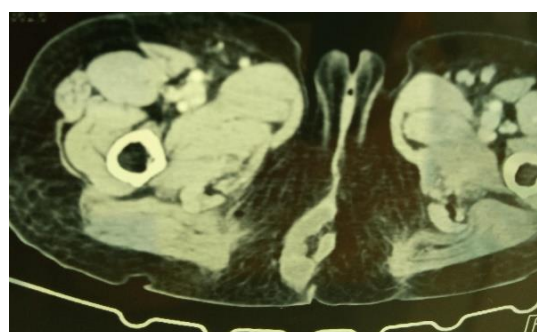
CT scan of the pelvis showed perineal hernia
